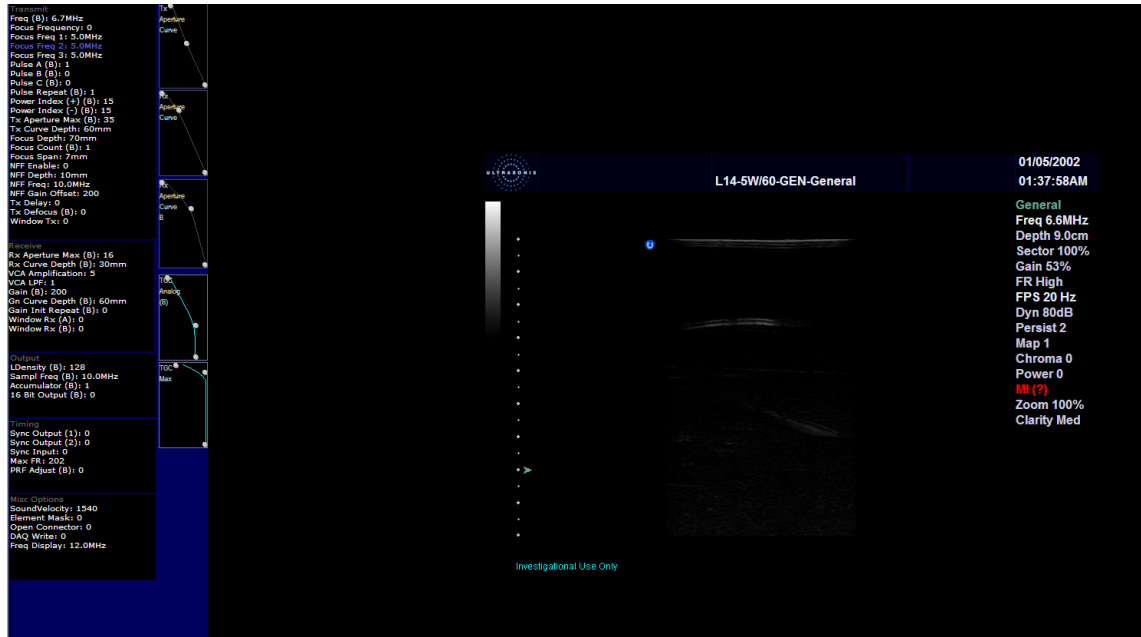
Ultrasound settings for EPT experiment
